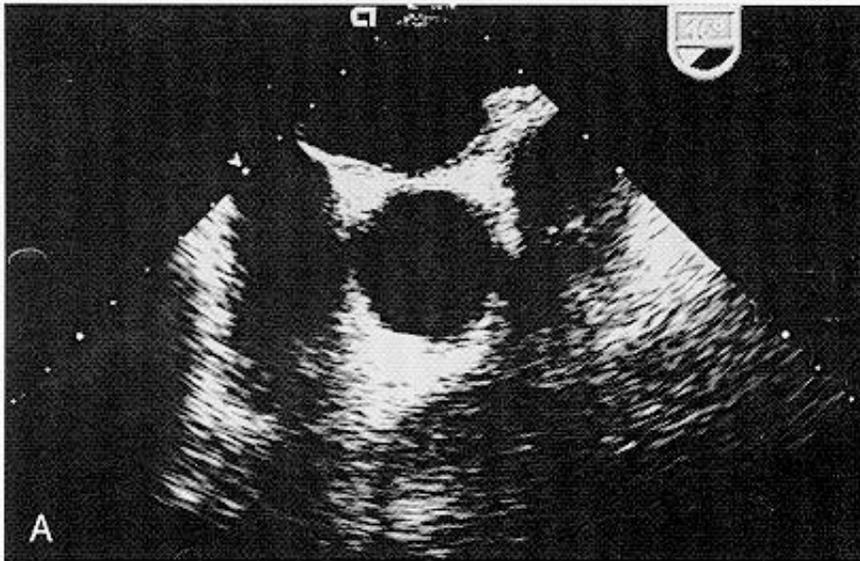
Short-axis view of single-disk valve (Medtronic Hall [Medtronic, Minneapolis, MN]) in aortic position. Imaging is just above level of annulus, and disk is not seen in closed position during diastole (A). During systole (B), open disk is oriented perpendicular to ultrasound beam.
